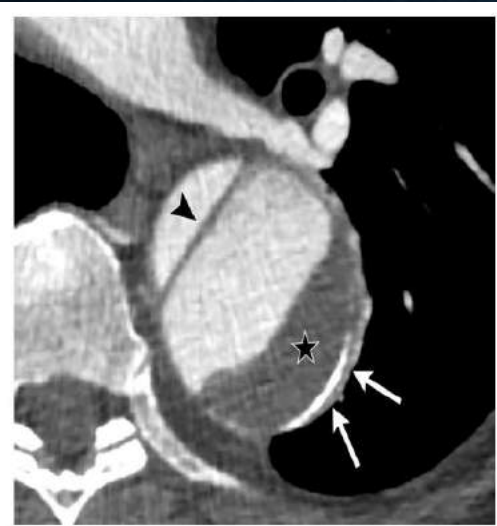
61 year-old male with an approximately 11 year-old chronic type B aortic dissection. CT scan at the level of the proximal descending thoracic aorta shows a straight flap (arrowhead), FL thrombus (star), and FL outer wall calcification (arrows)
